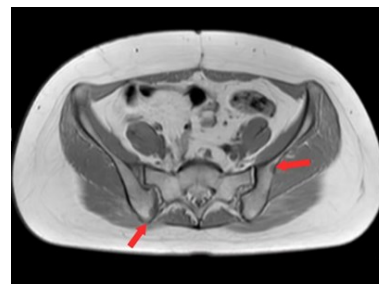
Pelvic magnetic resonance imaging revealed multiple patchy long T1 and long T2 signal shadows in both iliac and sacral bones, suggestive of multiple bone metastases in the tumor.
